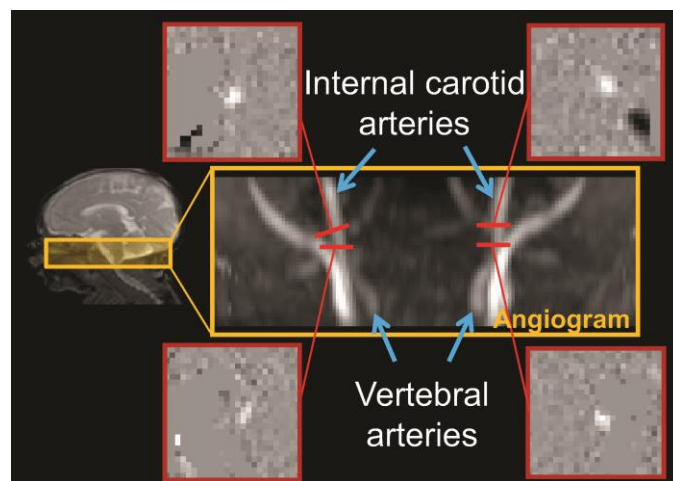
Phase-contrast (PC) MRI for global cerebral blood flow (CBF) measurement. The coronal view of the angiogram in the right middle panel shows the feeding arterials, namely internal carotid and vertebral arteries, with anatomical location of the 3D angiography delineated in a T2 weighted sagittal image on the left panel. The four slices of the PC MRI scans were positioned perpendicular to the respective feeding arteries on the angiogram, shown as red bars. The four phase images of the target arteries from the PC MRI scans are shown on the four panels surrounding the angiogram.
